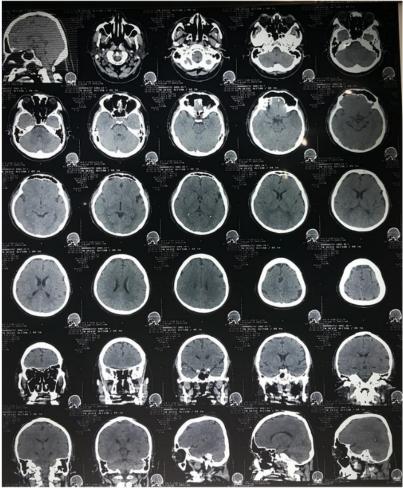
Head CT Scan within normal limits. No intracerebral hemorrhage was seen.
